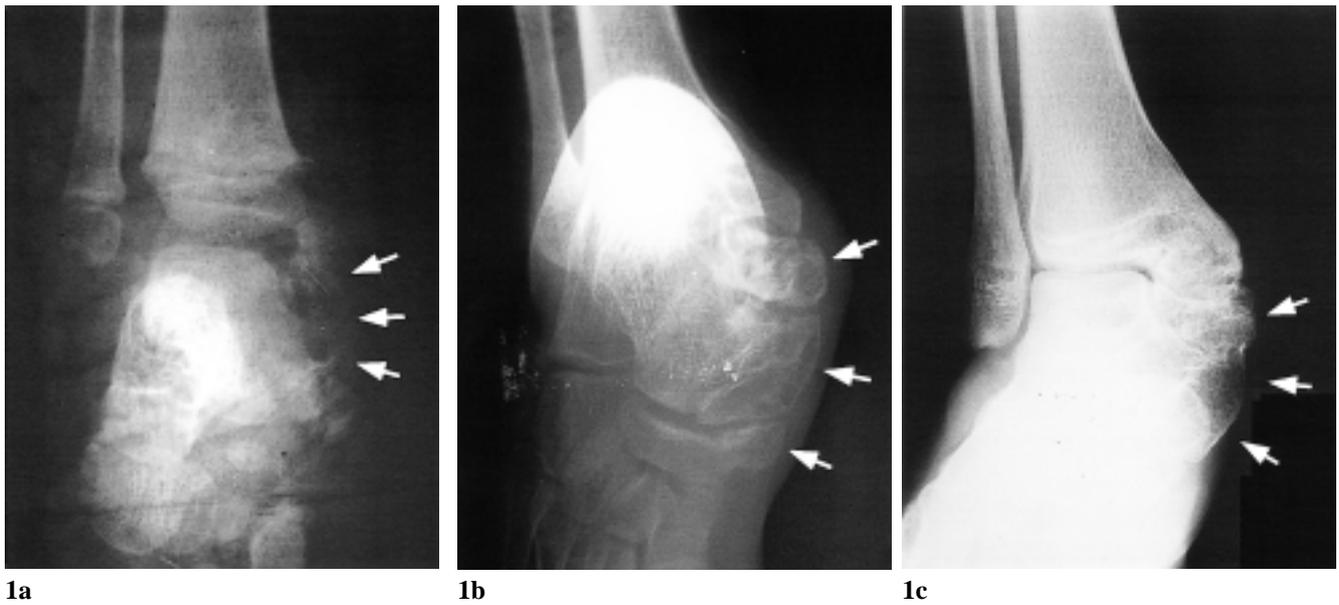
Serial lateral radiographs of right ankle in the case of Trevor's disease discloses progressive enlargement and confluence of the bony masses. a. At 3 years old, small faint osseous bodies over the medial aspect of the hind foot were noted (arrows), which were interpreted as posttraumatic bone fragments then. b. At 10 years old, confluences of the osseous bodies with tarsal bones (arrows) were found. c. At 21 years old, confluence and enlargement of the bony mass resulted in hind foot valgus.
